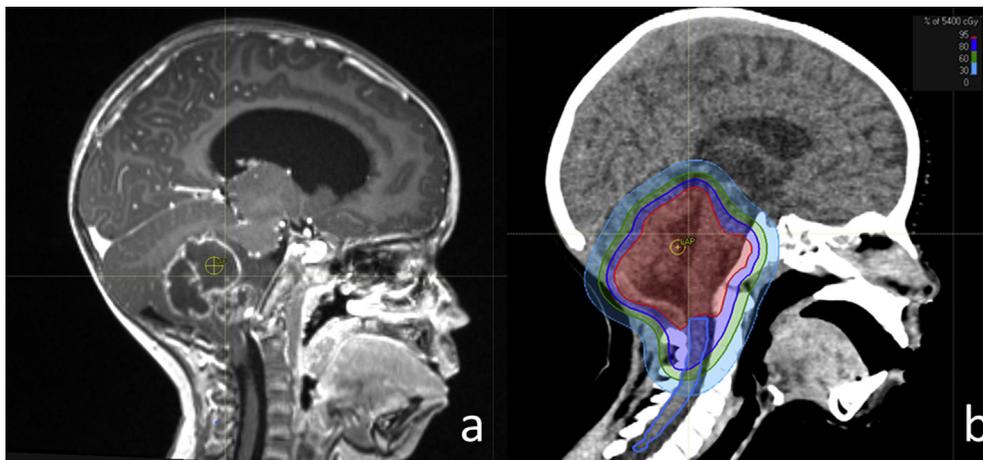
Diagnostic magnetic resonance image (sagittal section) (a) with corresponding pencil beam scanning proton therapy plan and dose distribution (b) for a child with ependymoma in the fourth ventricle (total dose of 54 Gy in 30 fractions, plans generated using RayStation®). Red area: region covered by 95% isodose line; dark blue area: 80% isodose; green area: 60% isodose; light blue area: 30% isodose.
